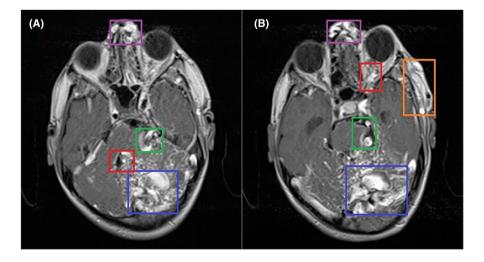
MRI brain and orbits. (A) Axial T1-weighted image with contrast enhancement demonstrates arteriovenous malformation (AVM) involving the left cerebellar hemisphere (blue box), the fourth ventricle (red box), the left cerebellopontine angle (green box) and the external nose (purple box). (B) Axial T1-weighted image with contrast enhancement demonstrates AVM involving the external nose (purple box), left maxilla and soft tissue (orange box), the left retrobulbar space causing mild proptosis (red box), the basilar cisterns (green box) and both cerebellar hemispheres, more on the left side (blue box).
